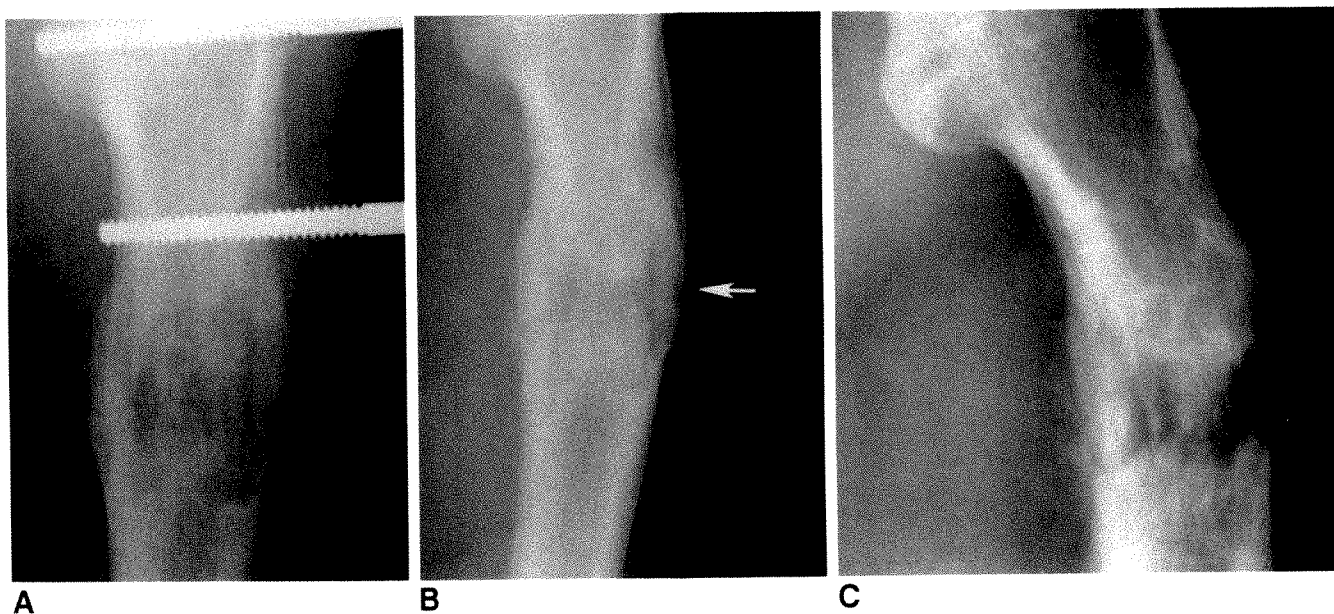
A–C, Serial anteroposterior radiographs before (A), and after (B, C) fixator removal. A subtle fracture (arrow) with slight varus angulation is present on first radiograph obtained after fixator removal (B). This was not recognized, and marked varus angulation developed (C).
